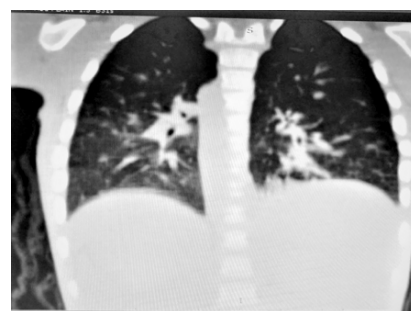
HRCT showing bronchiectasis with dextrocardia
